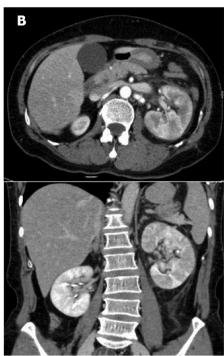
Acute pyelonephritis grades according to CT findings. (A) lesser grade, lesser than 50% of renal involvement (B) greater grade, greater than 50% of renal involvement.
